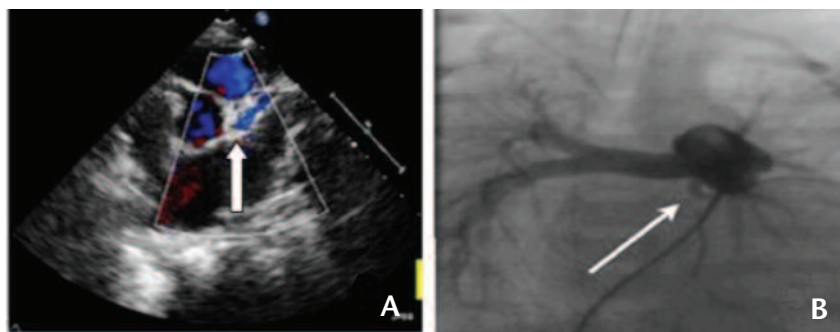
(A) Echocardiography in the upper parasternal short axis showed the absence of a connection between the left coronary artery and the aortic root (arrow), and reverse flow from the pulmonary artery. (B) Pulmonary aortography showed the origin of the left coronary artery from the main pulmonary artery (arrow).
